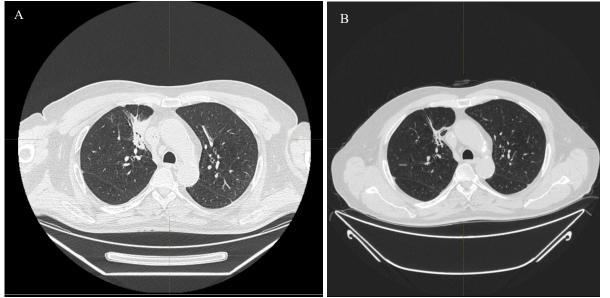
Computed tomography of the chest with in-vivo contrast: before treatment (A) and after 18 months of antitumor therapy (B).
